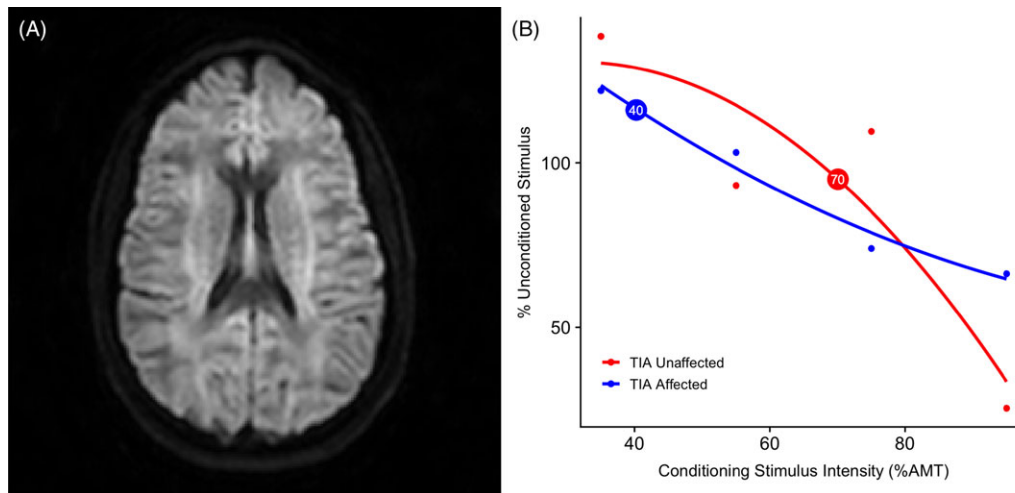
MR Imaging and TMS data from a representative subject with clinically diagnosed TIA at 14 d postsymptom onset. (A-B) DWI (A) and FLAIR (B) sequences rated DWI negative for acute ischemia by study neuroradiologists. (C) TMS-derived metrics of short-interval intracortical inhibition (SICI) show differences in the threshold for inhibition in the TIA-affected and TIA-unaffected hemispheres. Plots are median amplitudes of motor-evoked potentials (MEPs) in the abductor pollicis brevis (APB) muscle at tested conditioning stimulus (%CS) intensities. Thresholds for SICI are indexed by the red circle, with the numerical value representing %CS intensity at threshold. Higher thresholds indicate reduced intracortical inhibition (i.e., as shown in the TIA-unaffected hemisphere in Panel C), because a greater intensity of TMS stimulation is required to evoke an inhibitory cortical response.
